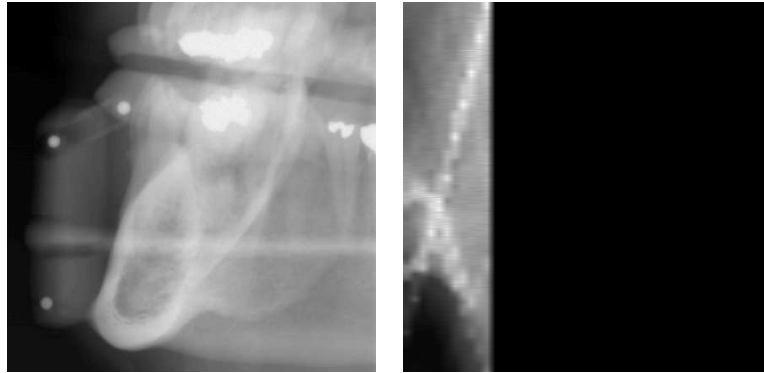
Left: One extraoral projection radiograph of the patient. Right: One slice of the 3D data in sinogram form.
